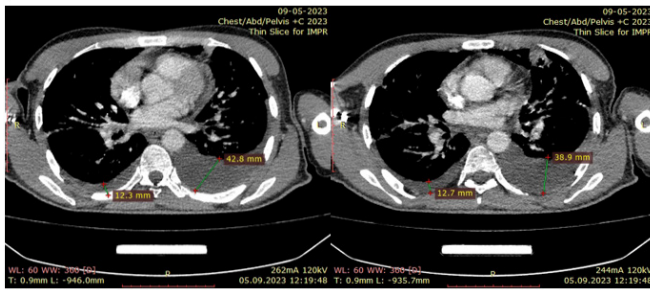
Chest CT scan (September 2023).
